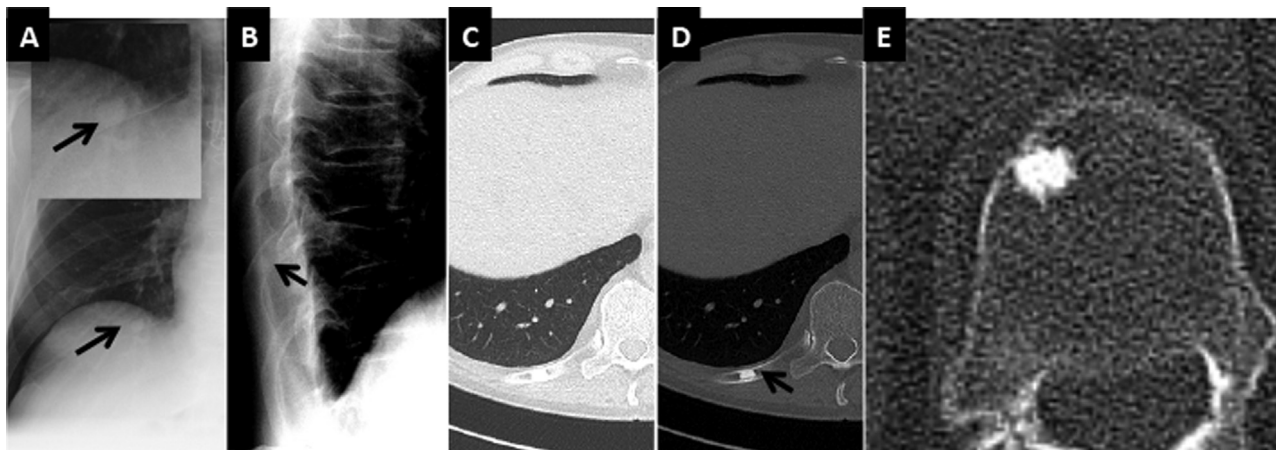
Bone island/enostosis: frontal chest radiograph (A) demonstrates an apparent right lower lobe nodule (arrow, inset). Retrospectively, the lesions can be localized to the right 10th rib on the lateral projection (B). Subsequent CT found no correlate in the lung (C) but there was an oblong sclerotic lesion within the rib at this level (D). Note that the bone island is oriented along the long axis of the rib (D). Axial CT image from a different patient (E) demonstrated the classic appearance of a bone island in the axial skeleton with spiculated “paintbrush” margins and a surrounding halo of lucency.
